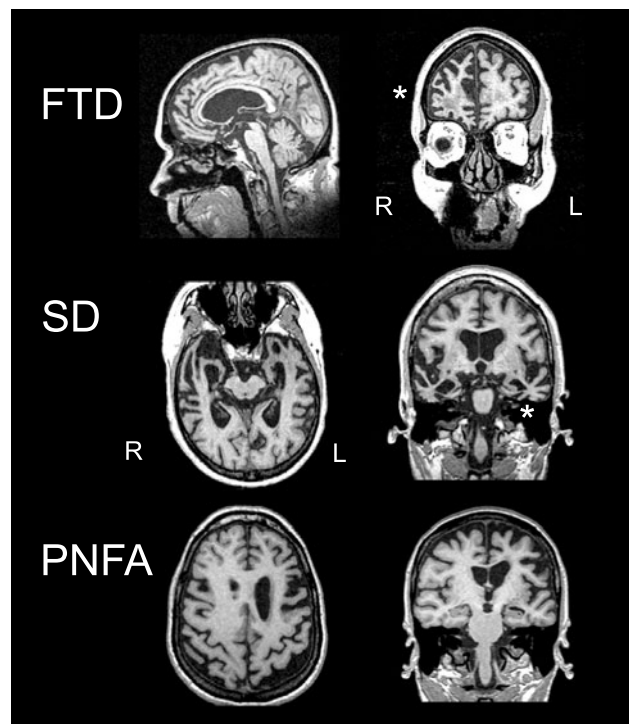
Magnetic resonance imaging findings in frontotemporal dementia (FTD).
